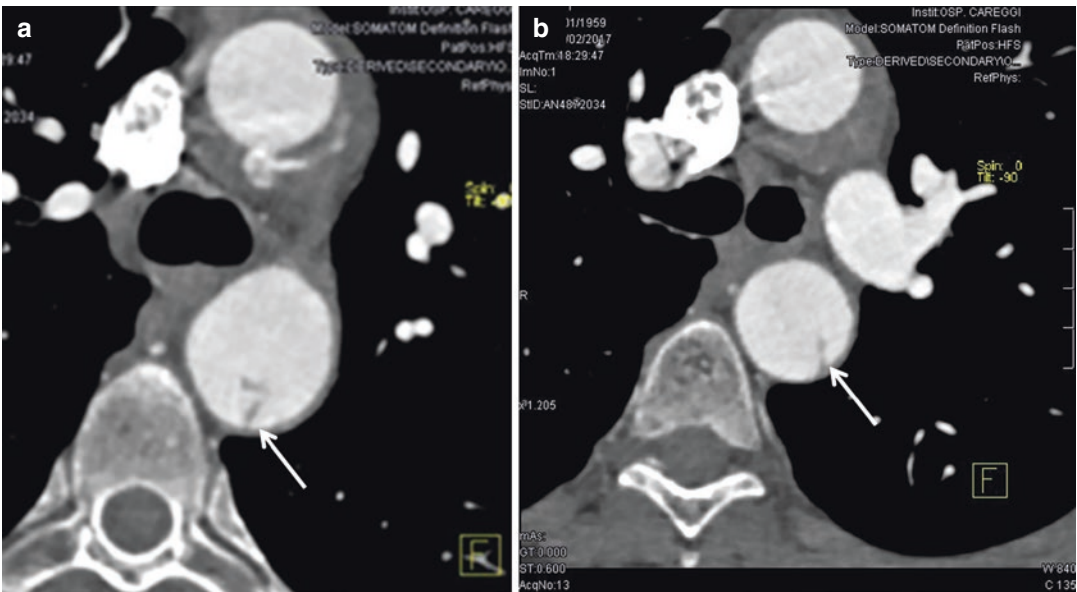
Axial CT scan shows in (a, b) (*white arrows*) intimal tear (intimal flap isthmus)
